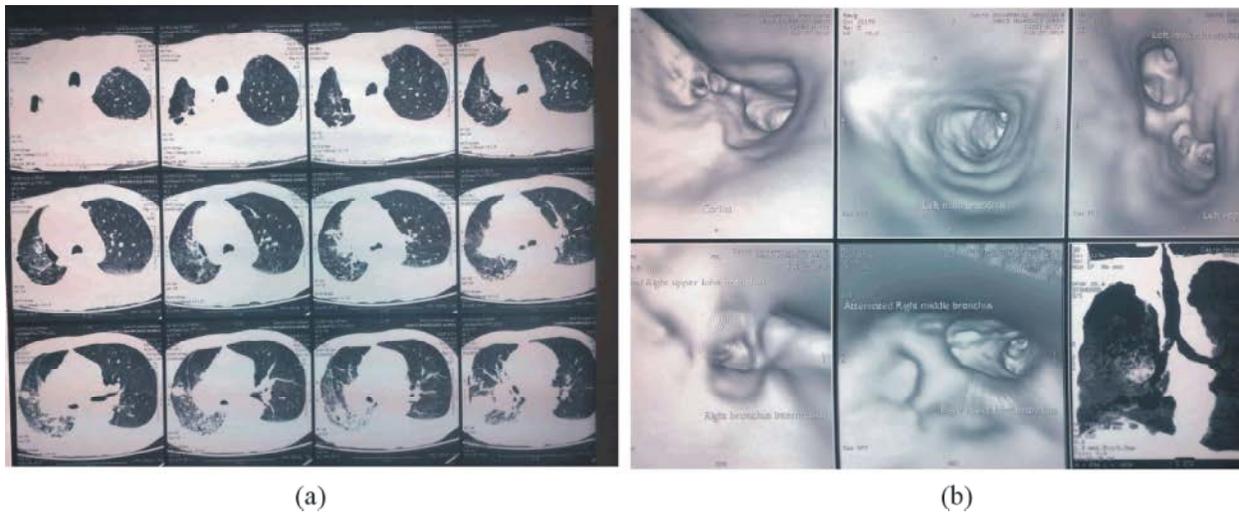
(a) CT chest shows right hilar mass (b) VB shows attenuated right middle lobe bronchus.
